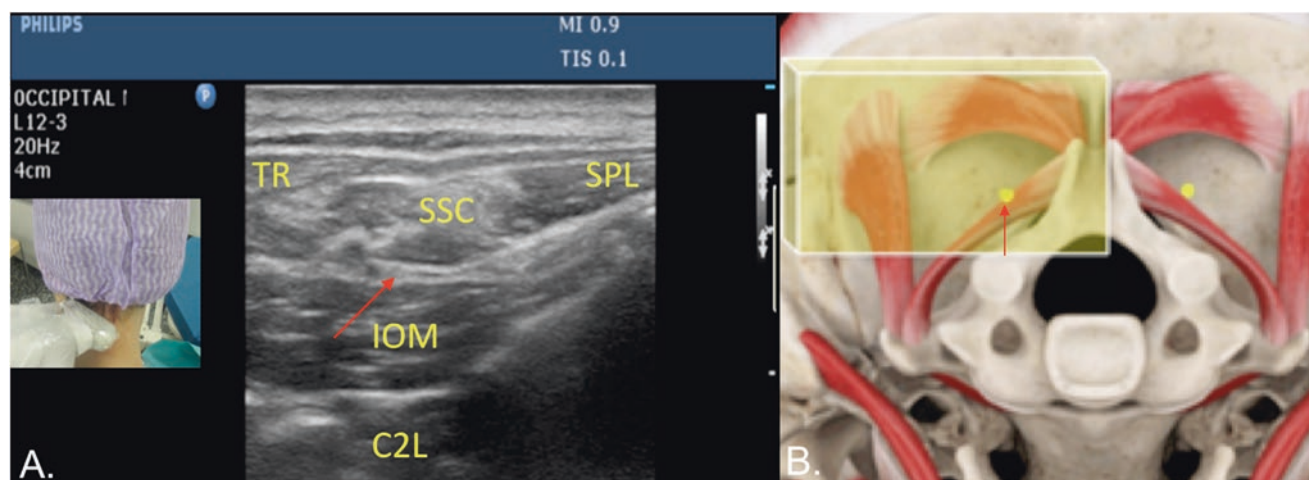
(a) Ultrasonographic image of greater occipital nerve (red arrows), injectate spread just above the GON. M medial, L lateral, C2L Ce lamina, IOM *m. inferior obliquus capitis*, SSC *m. semispinalis capitis*, TR *m. trapezius*. Inset orientation of probe tilted superolateral. Inset probe placement adapted from Greher
